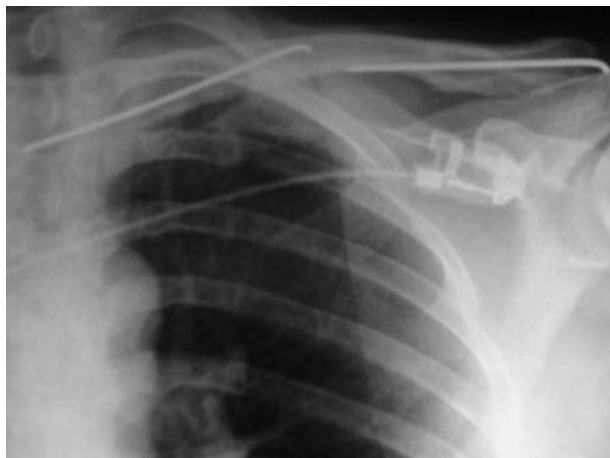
Chest radiograph, AP view. Note the migrated K-wire projecting in front of the spine, and its initial location with another K-wire still in place.
